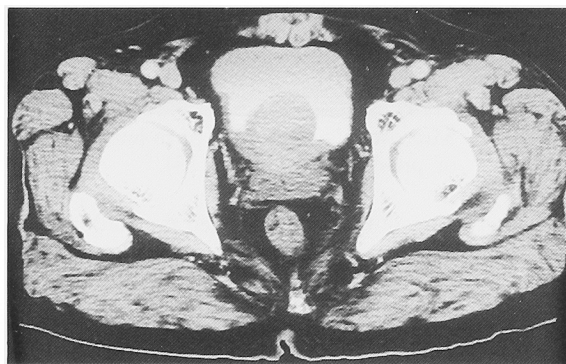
Computed tomography of the pelvis revealed an elevated mass in the bladder lumen.
